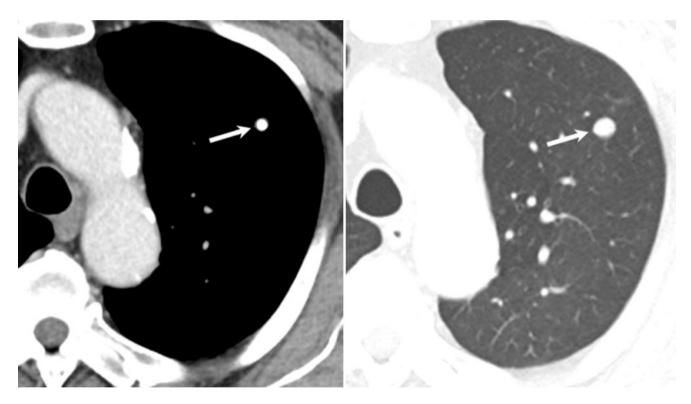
A 53-year-old man with a calcified granuloma (tuberculoma). Contrast-enhanced axial CT thorax image in soft tissue and lung window shows a well-defined, round calcified nodule in the left upper lobe (arrow)
